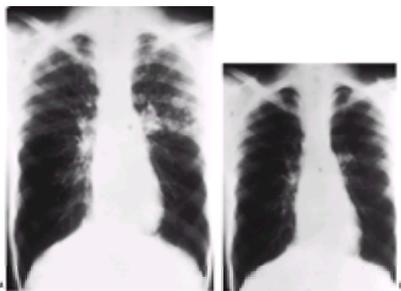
A: Chest roentgenogram of a patient with ABPA at the time of hospital admission. Note the radiodensities in the left upper lobe. B: Chest roentgenogram of the same patient as in A after 1 week of corticosteroid therapy. Note almost complete resolution of the radiodensity in the left upper lobe.
